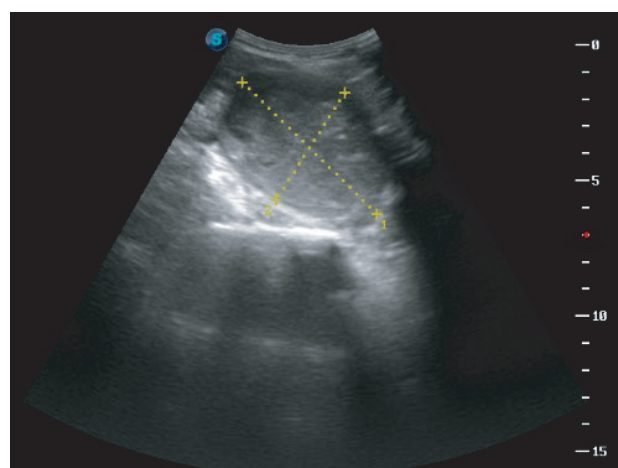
Ultrasonography of the cervico-mediastinal mass: hypoechoic structure with oval shape and well-defined margins.
